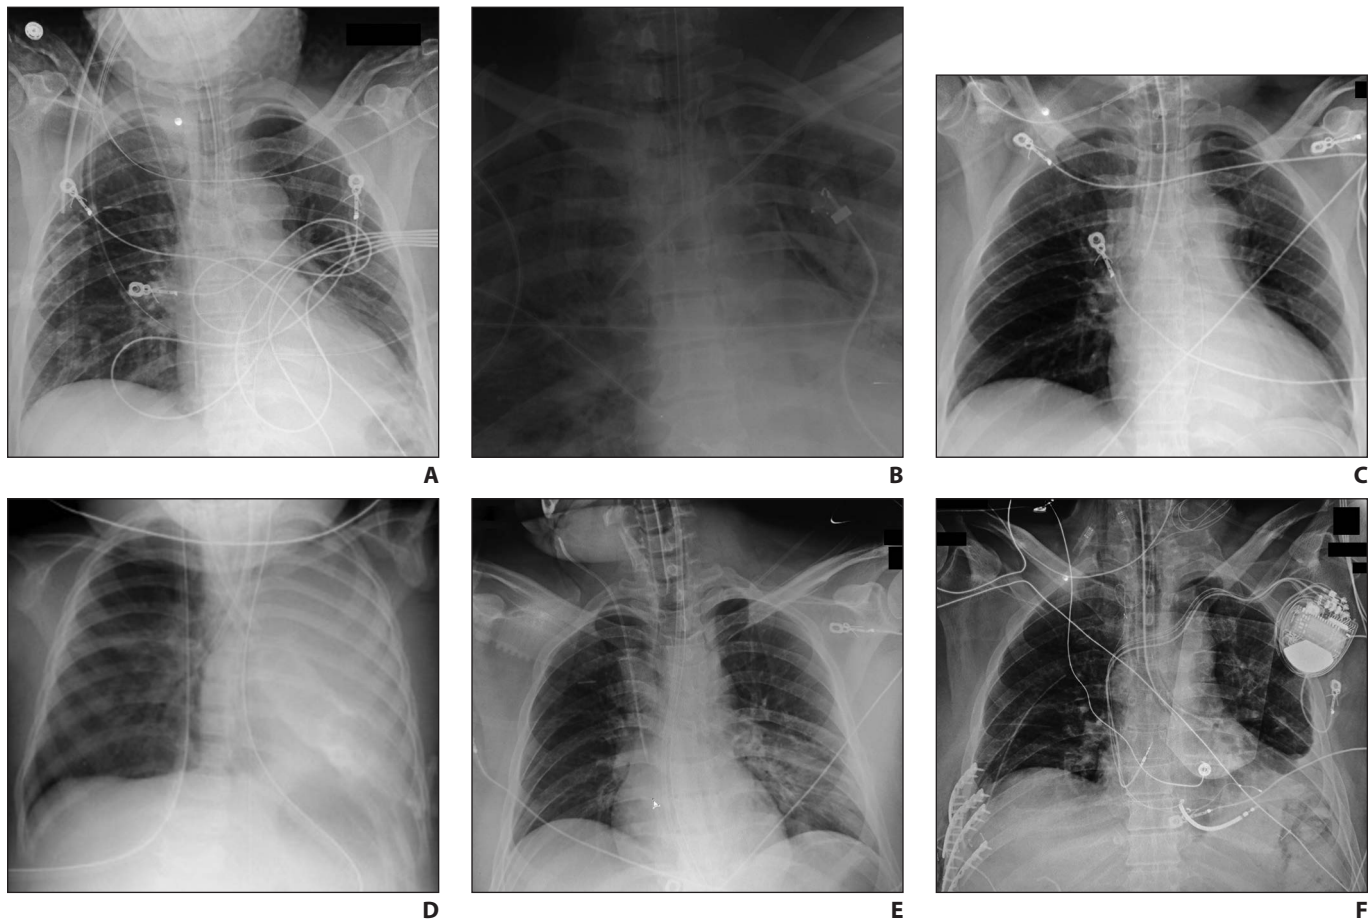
Well-positioned and malpositioned endotracheal tubes (ETTs) as shown on anteroposterior portable chest radiographs of six patients.
